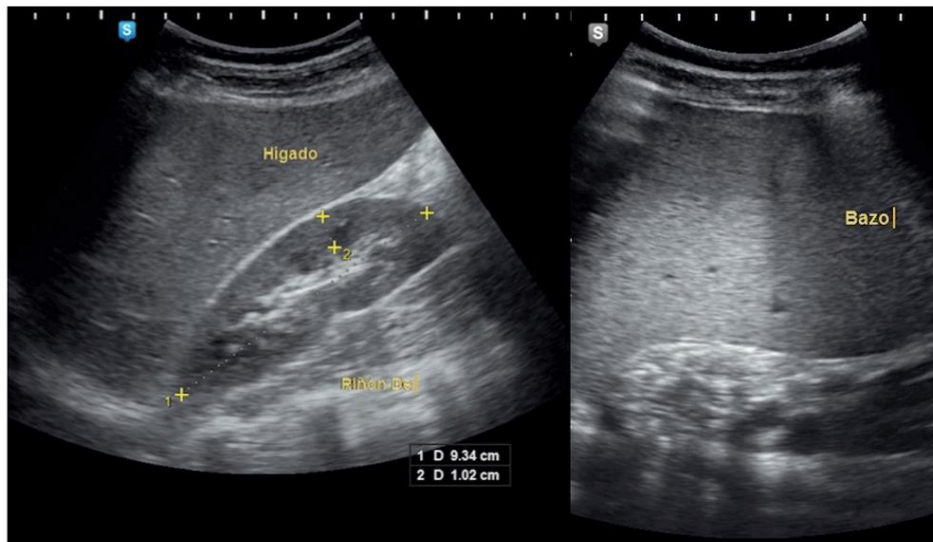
Upper abdomen ultrasonography where hepatosplenomegaly is observed.
